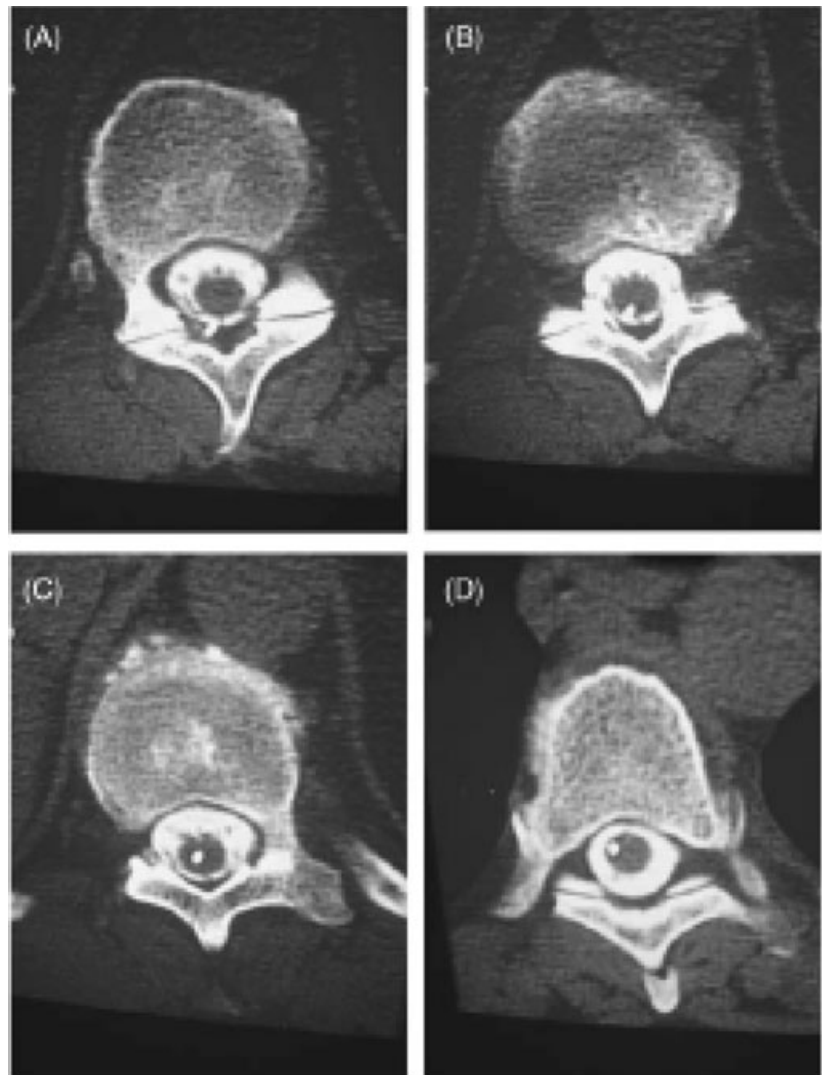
CT myelogram (A) demonstrates the entrance of the intrathecal catheter into the subarachnoid space. (B) The point penetrating into the cord. (C) The central intramedullary position of the catheter at the T11 level. (D) Catheter tip in the anterolateral quadrant of the spinal cord at the T7 level [3] (with permission).
